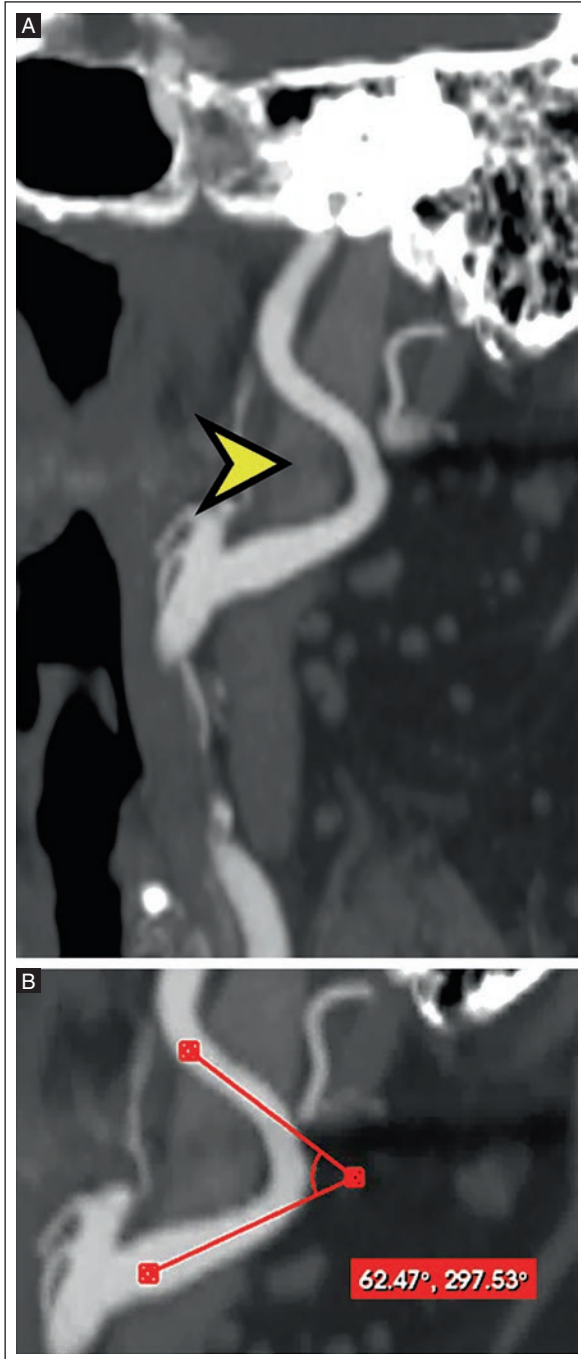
A: reconstruction of a neck CTA in the sagittal plane from a 74-year-old woman patient with kinking subtype A of EICA dolichoarteriopathy showing an angle less than 90° but more than 60° (arrowhead). B: magnified view with a measured angle of 62 degrees, classified as a grade I kinking subtype.
